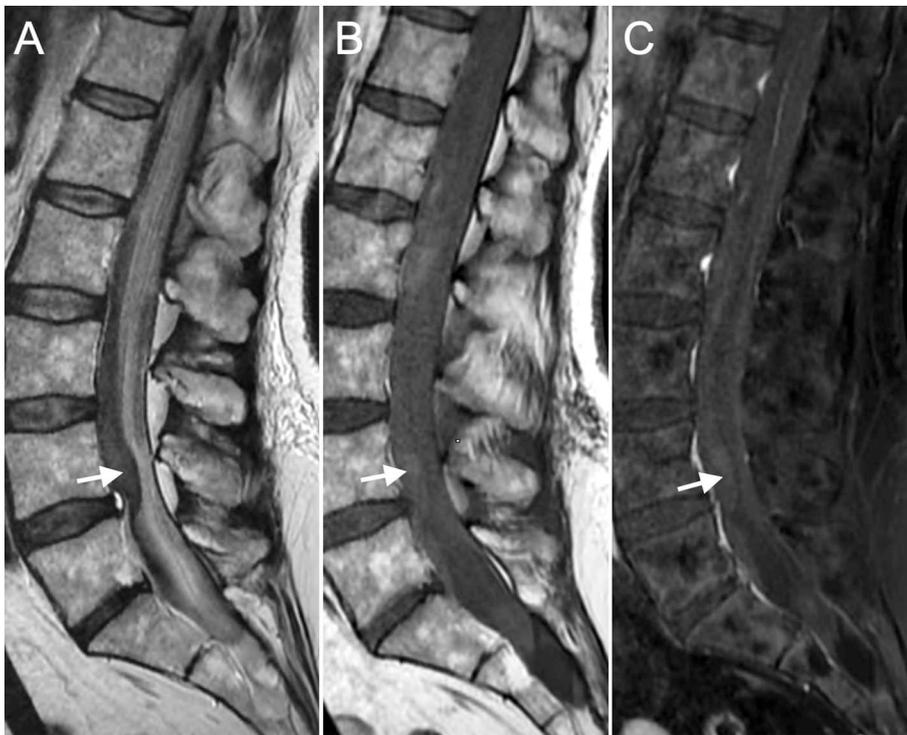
MR images depicting spinal subarachnoid hemorrhage. Lumbar sagittal T2 (A), sagittal T1 (B) and post-gadolinium fat-saturated T1 (C) weighted MR images reveal abnormal signal changes in the dural sac. Significant hypointensities on T2 and iso/hyperintense signal changes on T1 in the dural sac (arrows) are seen consistent with subarachnoid hemorrhage. No abnormal contrast enhancement is seen.
